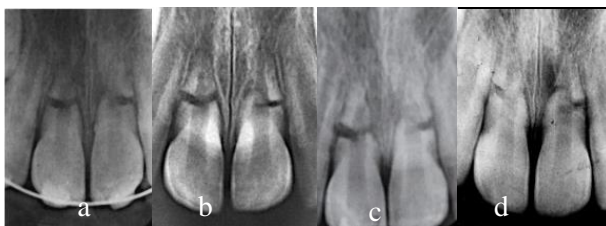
Periapical radiographs in the follow-ups: (a) 2 weeks after trauma, (b) 1 month after trauma, (c) 18 months after trauma, (d) 3 years after trauma
